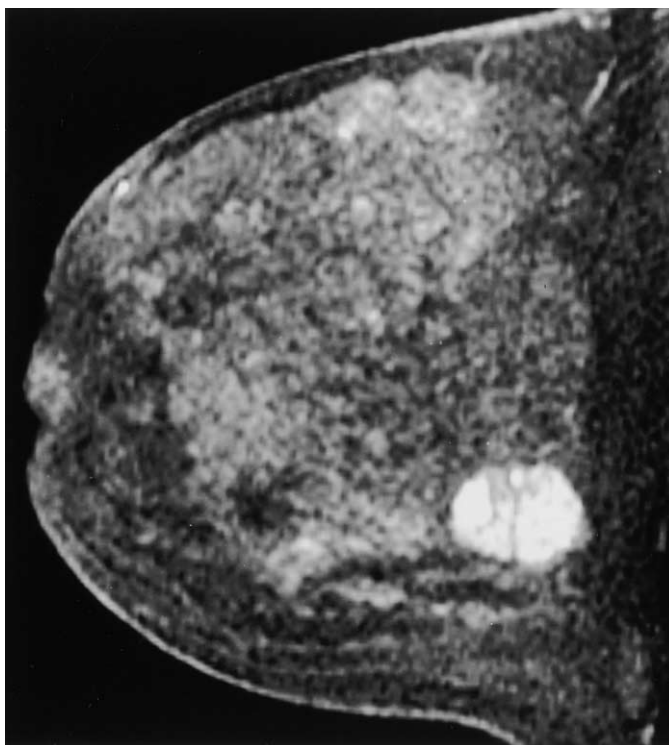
MRI of fibroadenoma. Sagittal, T1-weighted, contrast-enhanced image shows a lobulated enhancing mass with non-enhancing internal septations.
